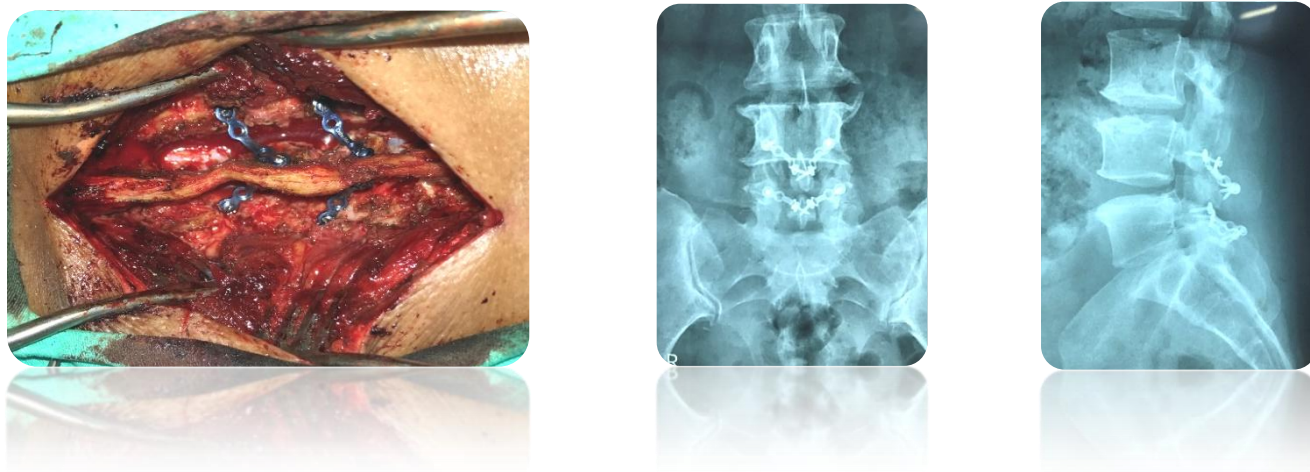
Per-operative imaging showing laminoplasty with plate and screws placement and postoperative x-ray.
